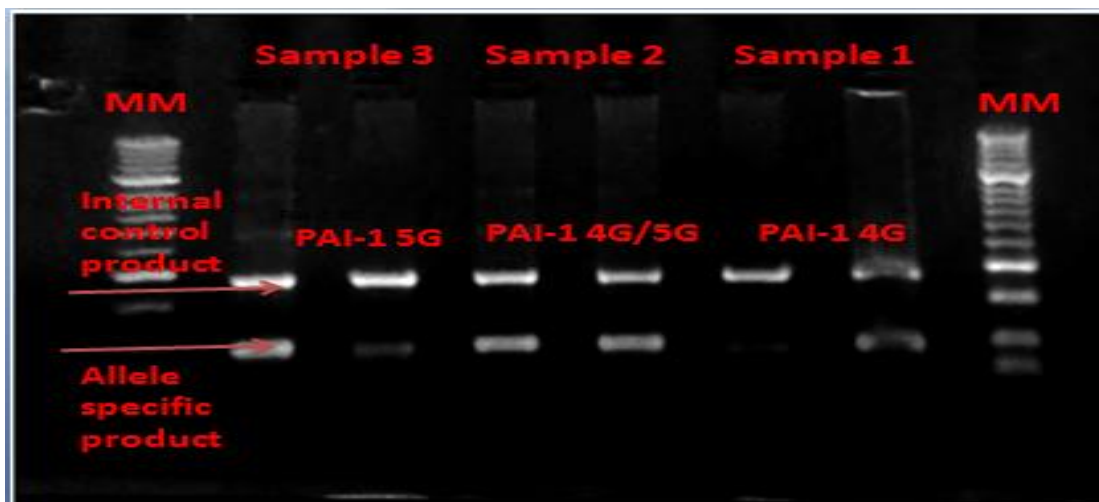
Electrophoresis of amplified DNA for plasminogen activator inhibitor type 1 from female menorrhagia in 2% agarose gel by using (APSMAG TAQ 2XPCR Master mix) and visible by UV light.
